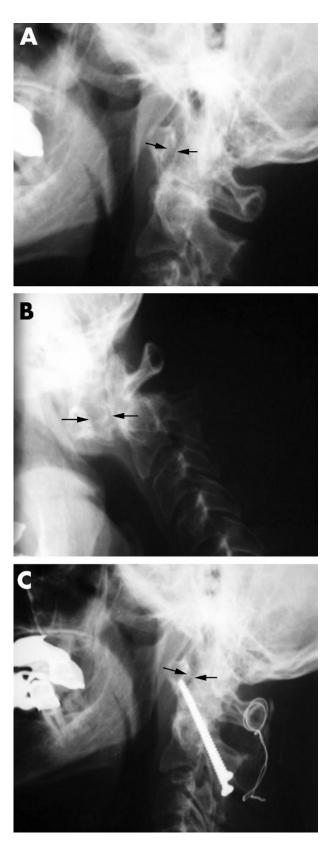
Lateral radiographs of the cervical spine during extension (A) and flexion (B) of the patient's neck. Severe atlantoaxial subluxation becomes evident in the flexed position where the distance (arrows) between the posterior surface of the anterior arch of the atlas and the anterior surface of the odontoid process widens to more than the normal \leqslant 3 mm. (C) X ray of the cervical spine of the same patient after surgical stabilisation.
